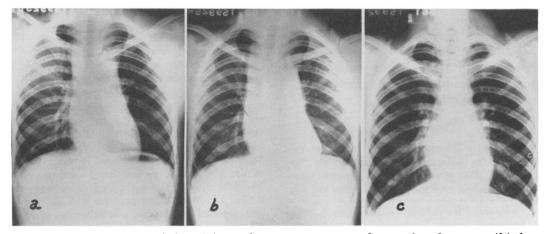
Roentgenograms of chest (a) on admission suggesting widening of mediastinum, (b) four hours after admission demonstrating progressive widening of mediastinum, and (c) at time of discharge from hospital.
